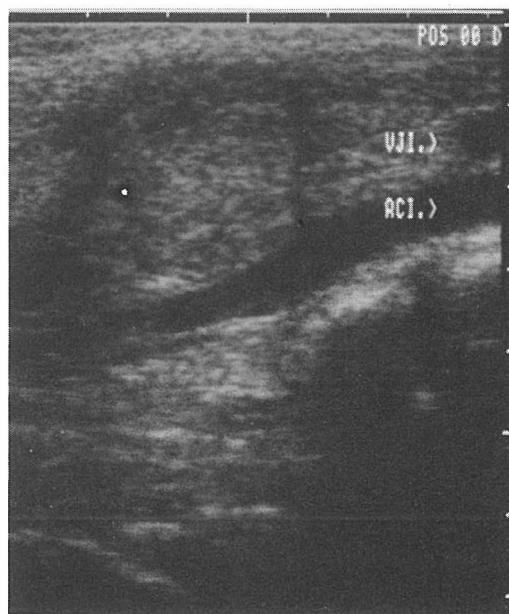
Destruction of the internal jugular vein (VJI) and compression of the internal carotid artery (ACI) with metastatic deposit. The arterial wall is intact (conventional sonography, 5 MHz).
